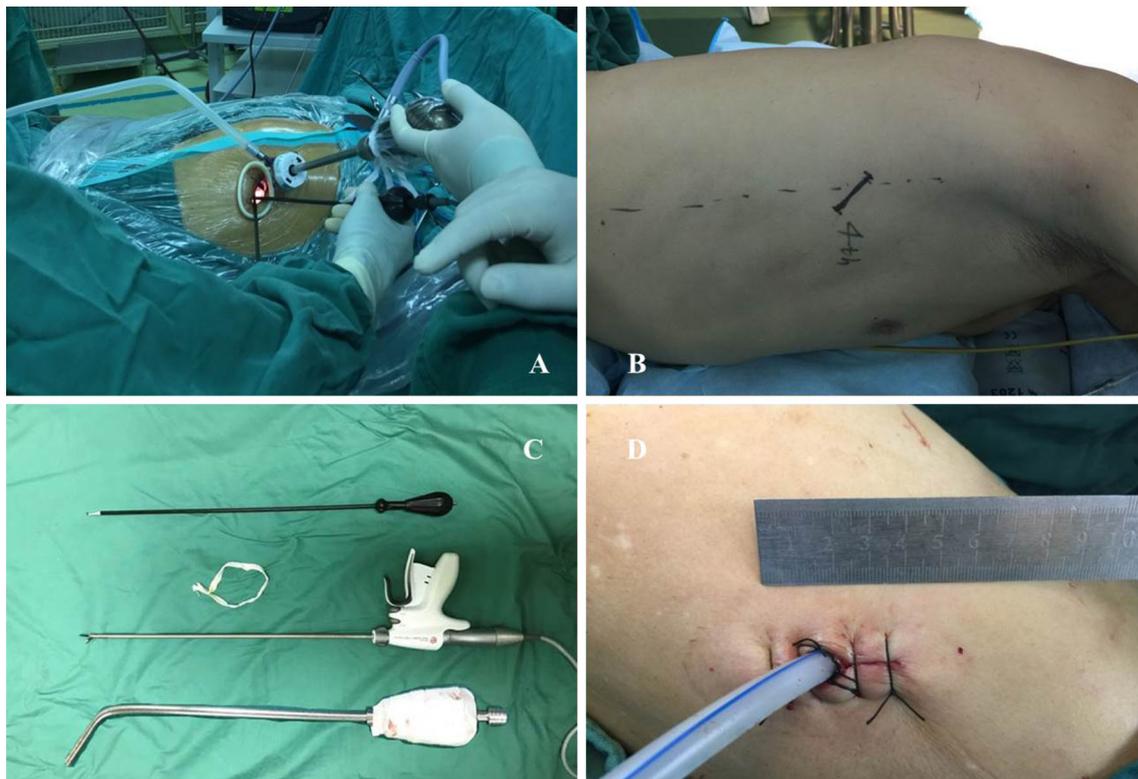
a Position of instruments and operators; b Site of chest incision; c Hook cautery, ultrasonic harmonic scalpel, esophageal traction belt and elbow suction apparatus; d Postoperation chest incision
